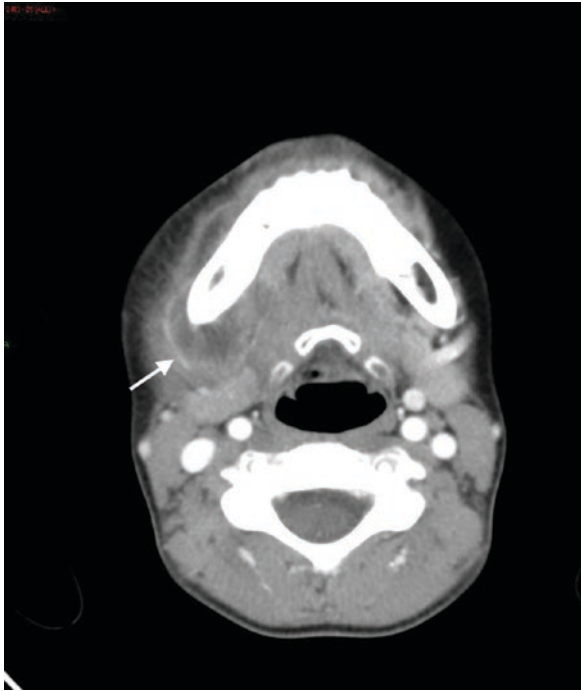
Submandibular abscess secondary to dental abscess. Axial contrast-enhanced CT image demonstrates a rim-enhancing collection within the soft tissues below the right side of the mandible. The infection has spread from a dental abscess (same patient as Fig. 2.74)
